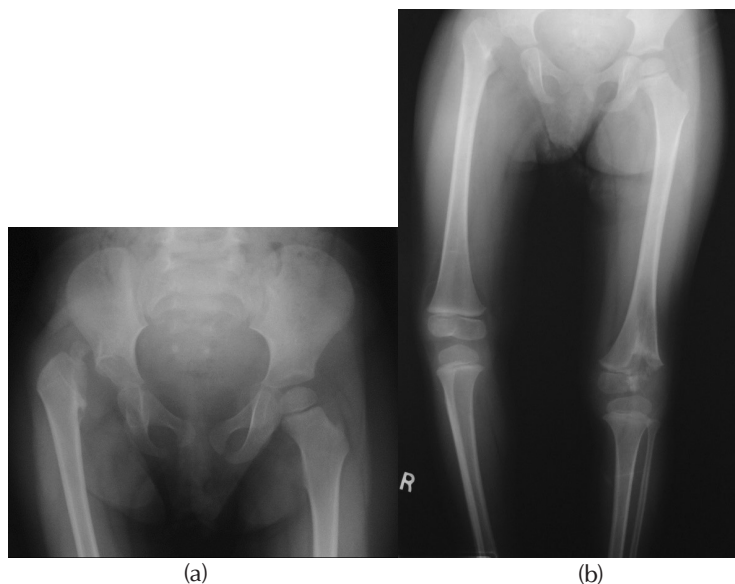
a) Radiograph showing pathological right hip dislocation at the age of 2 years due to a missed septic arthritis during infancy; b) Radiograph at the age of 2 years showing the left distal femoral condyle partially unossified as a result of knee sepsis during infancy.
